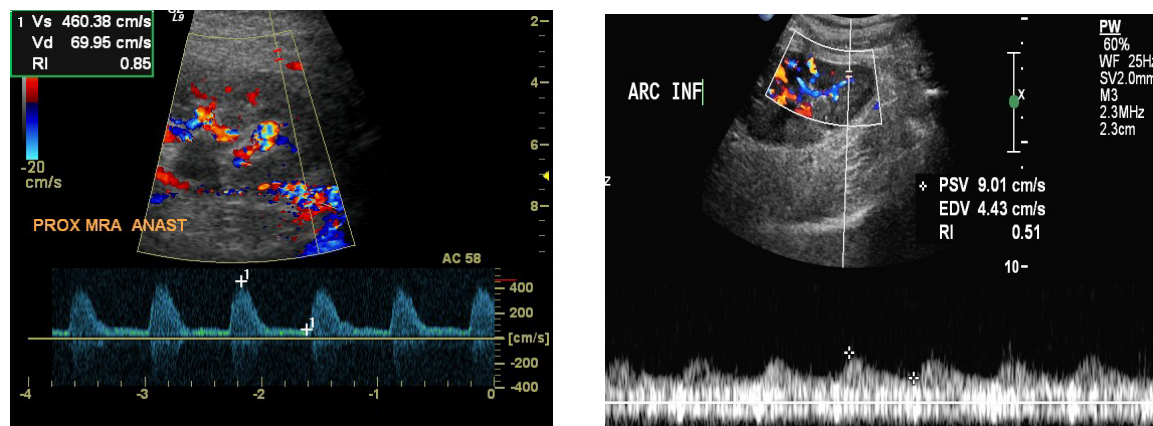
Renal artery stenosis. (A), a color Doppler and spectral waveform image through the anastomotic region of the transplant renal artery shows increased velocity (460 cm/s) through the anastomotic area. (B), a color Doppler and waveform through the intrarenal arcuate artery shows a delayed and slow upstroke with a 'tardus-parvus' waveform.
